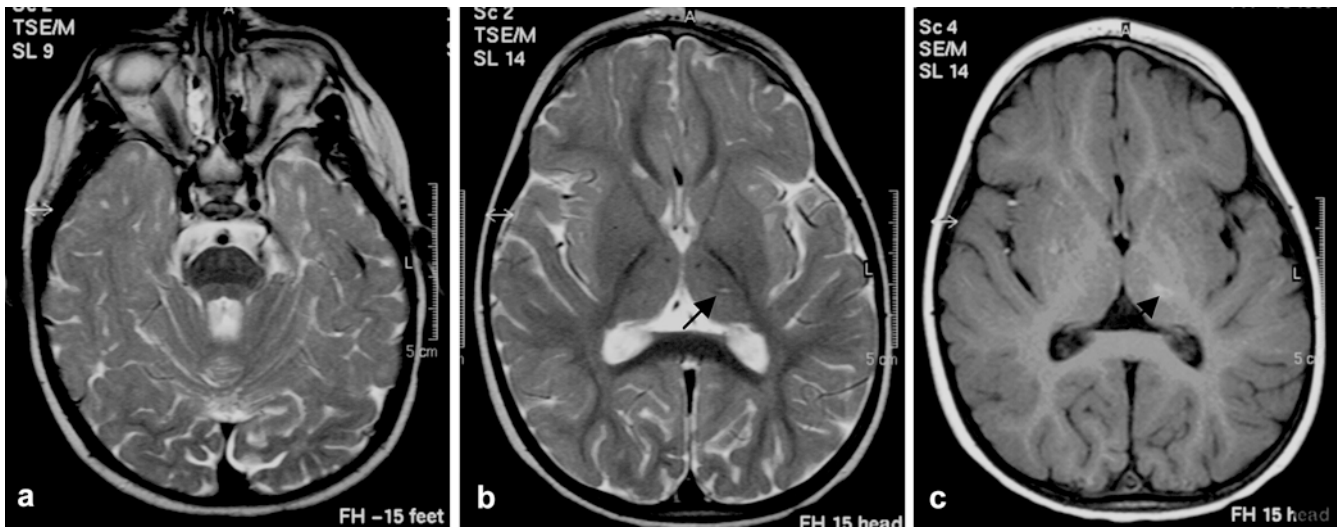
Follow-up examination of the same patient as Fig. 1, 4 months later. a, b There is almost complete resolution of the signal abnormalities on T2-weighted images. There is a small residual hyperintensity within the left thalamus (*arrow*) with a corresponding hyperintensity (*arrow*) on the T1-weighted sequence representing methaemoglobin (c)
